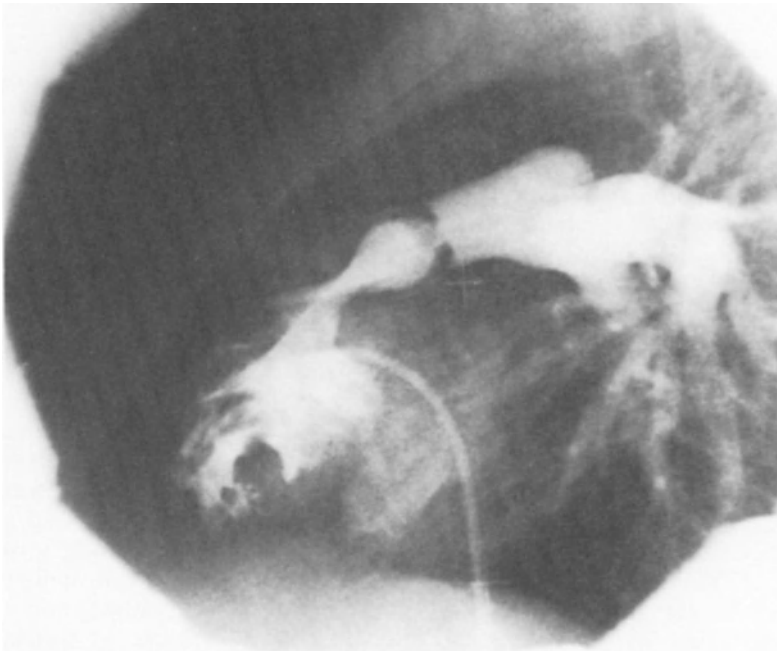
Lateral roentgenogram of a dysplastic pulmonary valve before balloon dilation valvuloplasty. Despite marked leaflet thickening and poor mobility, the gradient fell from 80 mmHg to 40 mmHg
